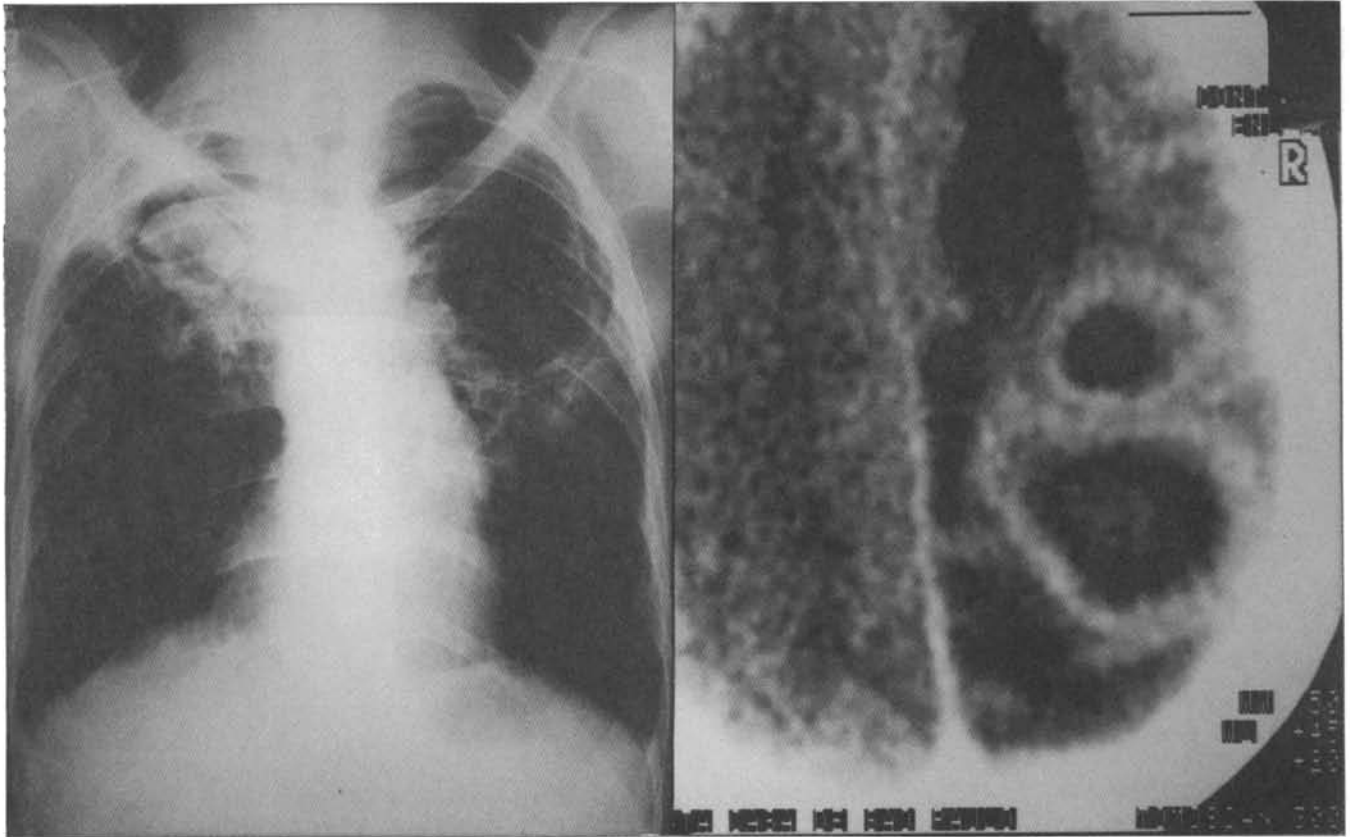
Left (A). Chest x-ray shows well-defined "Fungus Ball" within a thick-walled right upper lobe cavity. Right (B). Contrast-enhanced, computed tomography reveals two large brain abscesses in the right parietal lobe.
